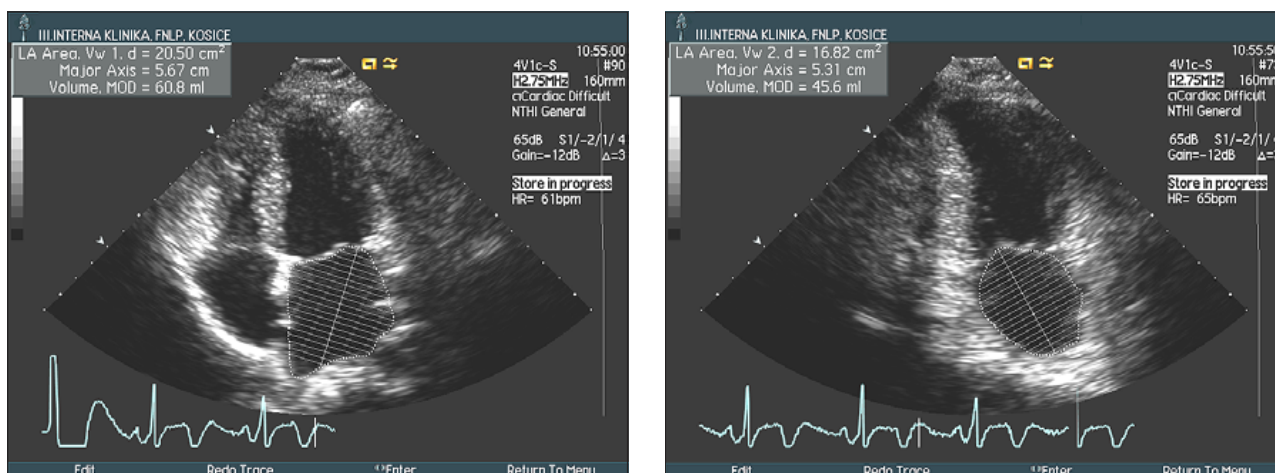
Measurement of the left atrial volume by biplane Simpson's method in apical four (A) and two-chamber view (B).
